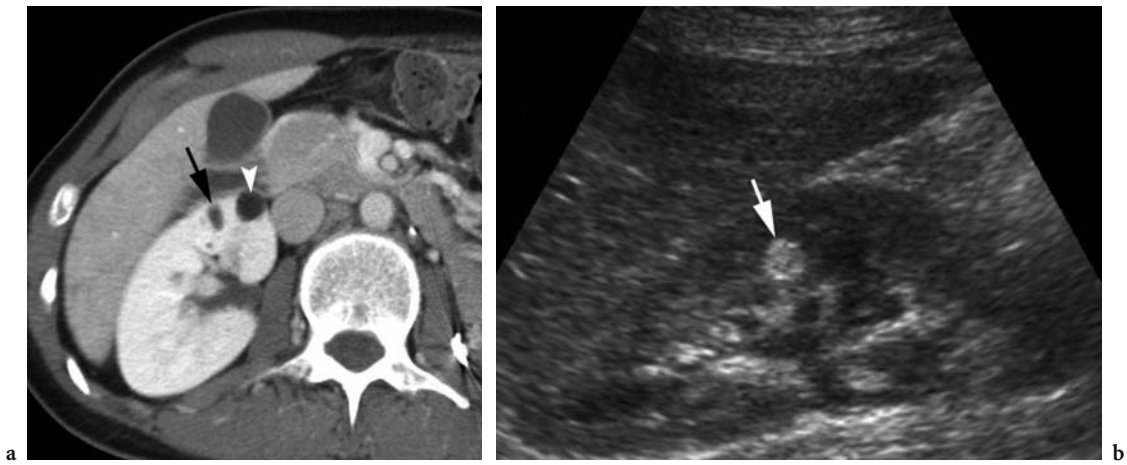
Tuberosclerosis in a 37-year-old woman. a Axial contrast-enhanced CT scan shows two small (5 and 10 mm) angiomyolipomas of the right kidney that measured -70 HU (*arrow*) and -80 HU (*arrowhead*). b Sagittal ultrasound shows a hyperechoic 1-cm angiomyolipoma in another part of the same right kidney (*arrow*).
